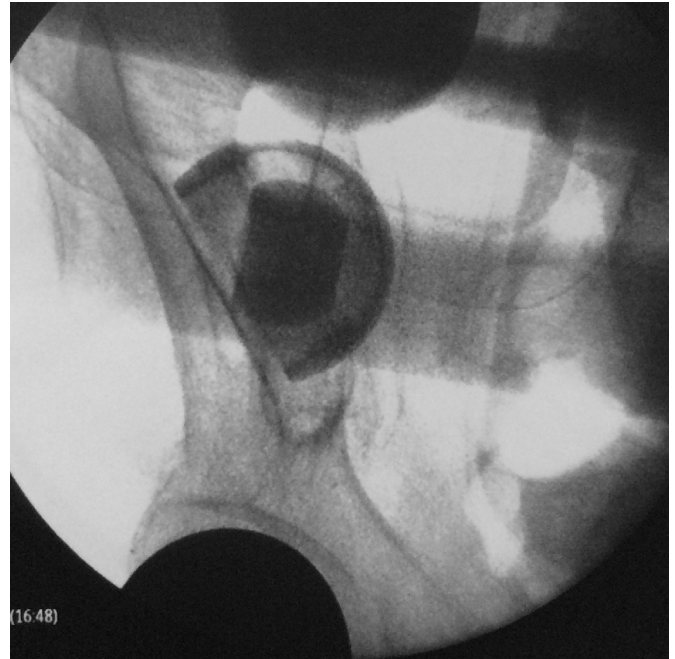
Radiograph of migrating trial bipolar cup.
